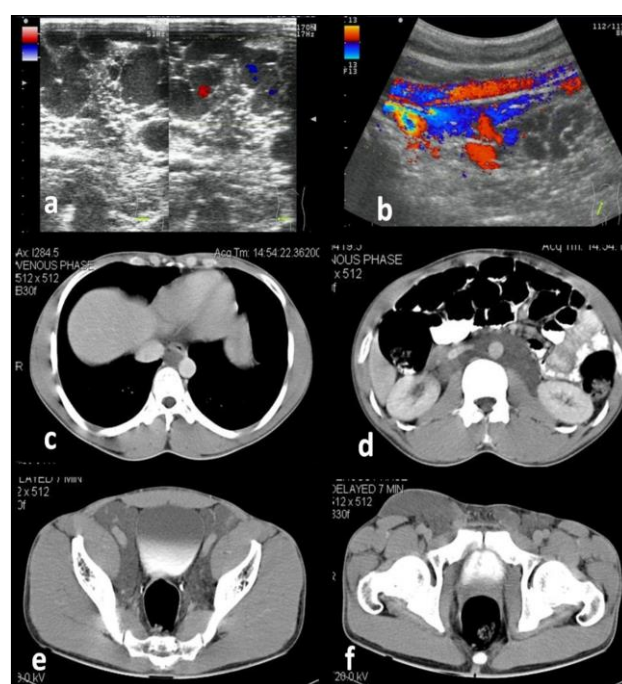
(a) USG abdomen axial images in right iliac fossa region showing elongated, tortuous, cystic, anechoic spaces seen bilaterally in retroperitoneum. (b) On colour Doppler examination, the tortuous spaces showed suspicious flow seen along right common iliac vessels in oblique sagittal image. (c) CT scan of abdomen and pelvis in venous phase, axial image shows dilated cisterna chyli in section at diaphragmatic level, (d) nonenhancing retroperitoneal cystic lesion in paraaortic region, (e) cystic lesions insinuates along both iliac vessels, (f) lesion in right inguinal region.
